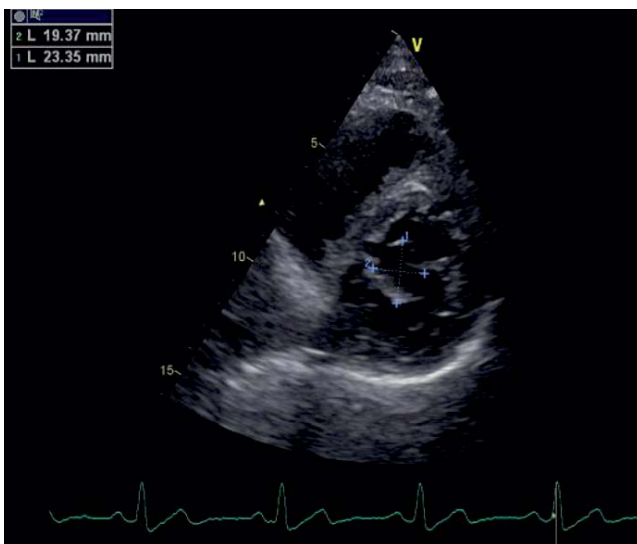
TTE parasternal short axis, visualization and measuring of the blood cyst.
